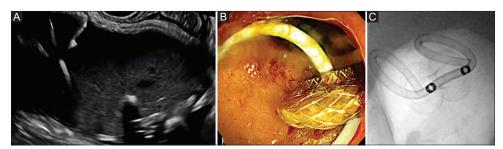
Endoscopic ultrasound-guided gallbladder drainage. (A) Endosonographic appearance of a hydropic gallbladder, with thickened walls and full of sludge, with release of the distal flange of a lumen-apposing metal stent (LAMS). (B) Proximal flange of the LAMS released in the bulb with coaxial double-pigtail stent (DPS). (C) Fluoroscopic view of LAMS and coaxial DPS
